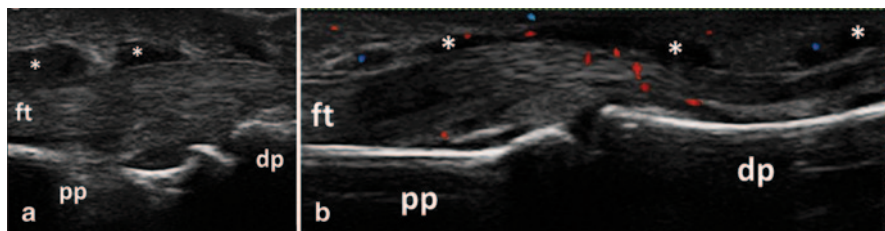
Longitudinal view of the palmar aspect of the proximal interphalangeal joint showing B-mode flexor tenosynovitis (asterisk) (a) with Doppler signal (b); *ft* flexor tendon, *pp* proximal phalanx, *dp* distal phalanx
